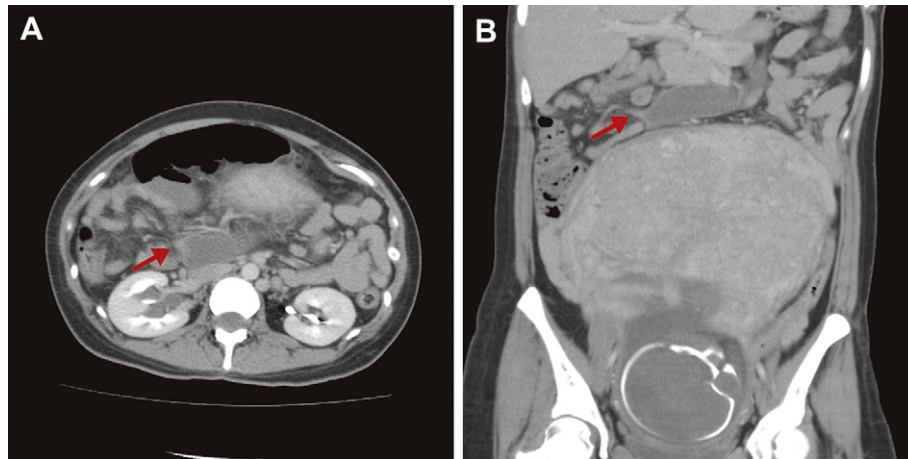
(A) Axial view of upper abdominal computed tomography (CT) scan. The bird-beak shape indicates the obstructive level of duodenum-jejunum junction (red arrow). (B) Coronal view of upper abdominal CT scan. The same bird-beak shape could be identified (red arrow). The distended intestine was at the proximal end.
